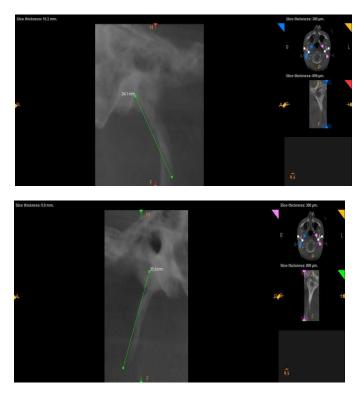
The length of the styloid process when measured on the CBCT was found to be 34.1mm on the right side and FIGURE 6B styloid process measuring 35.6mm on the left side
